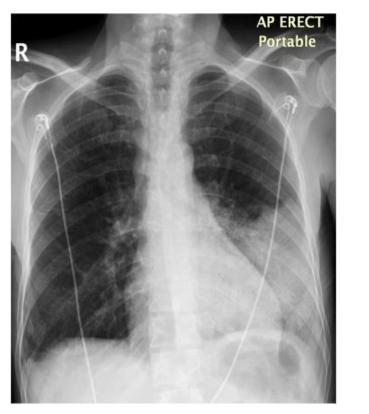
Left lower zone consolidation suggestive of lobar pneumonia- in this unlikely pattern chest radiograph (43).
